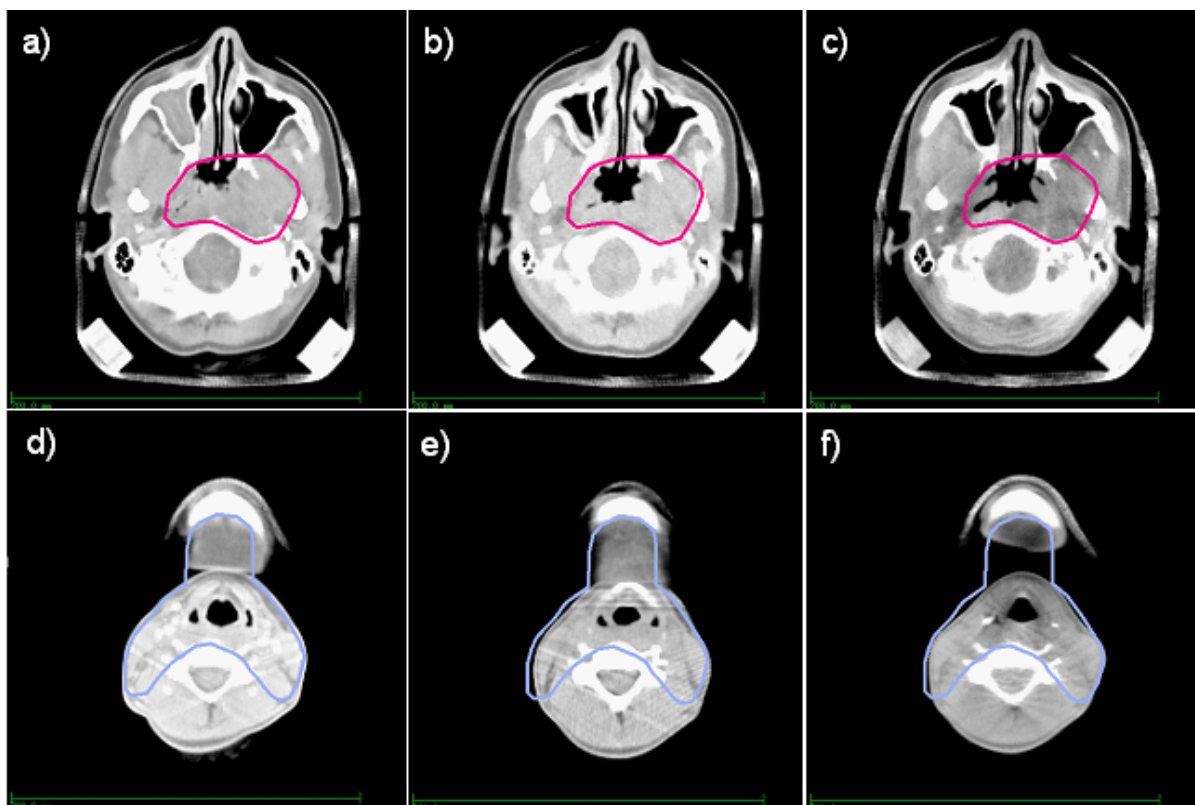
Patient #15 – planning-, control- and CBCT
